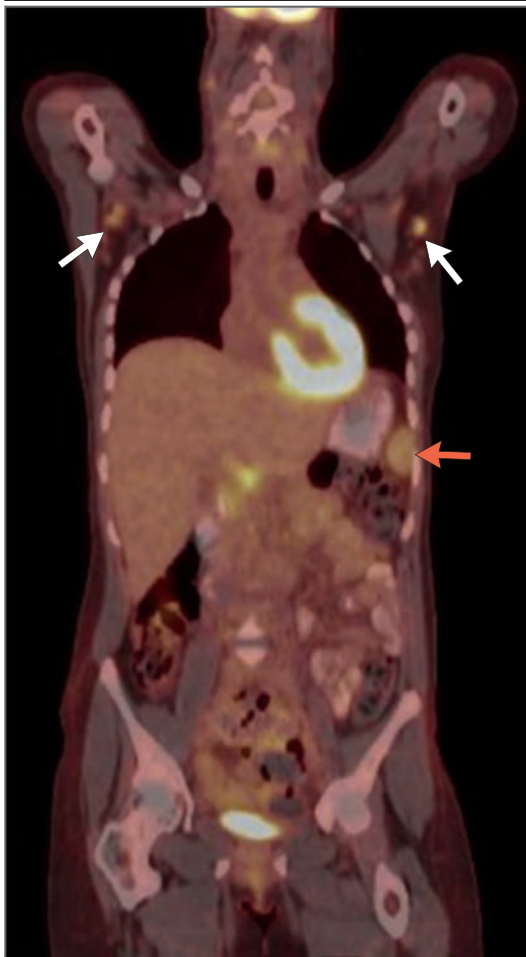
Coronal View of Positron-Emission Tomography–CT.
